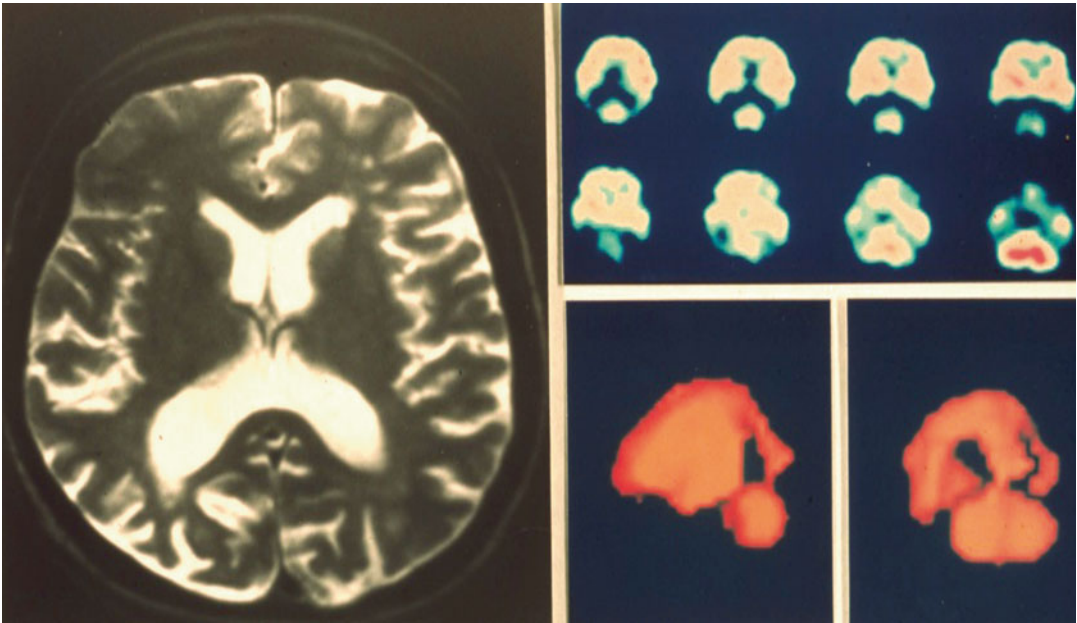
Brain SPECT in Alzheimer's disease (AD)
